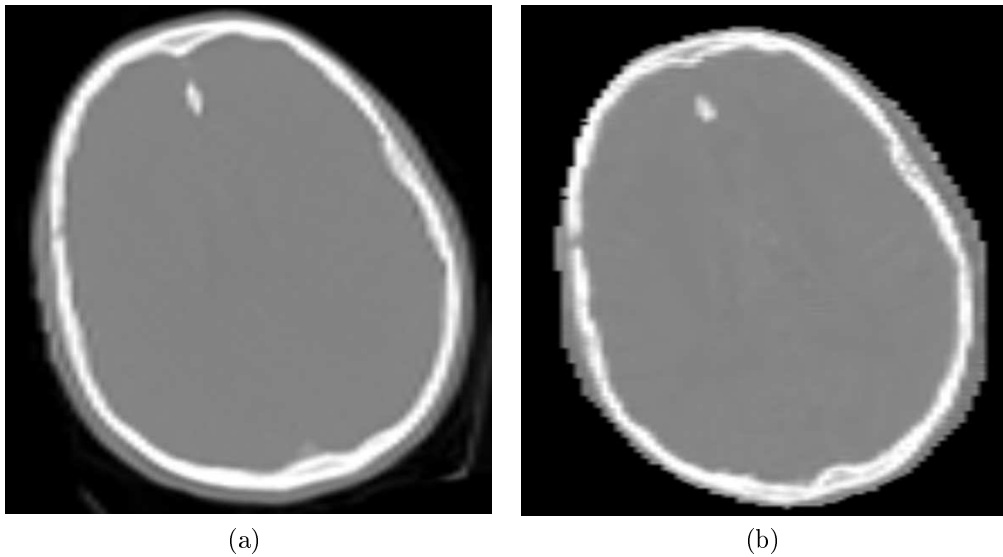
MR predicted CT (A) is able to identify calcifications in the brain (black arrow) in comparison to patient CT (B).
